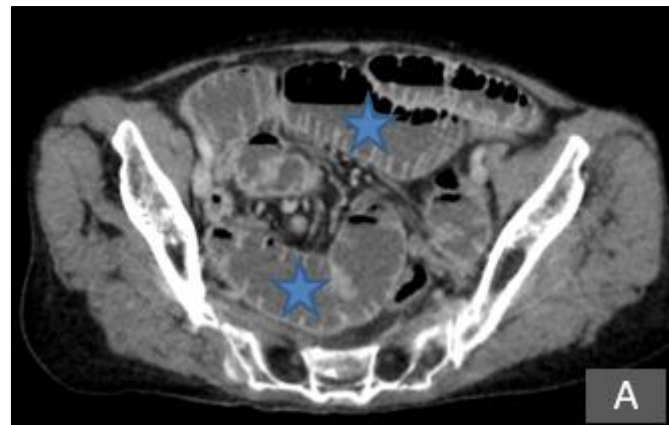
Abdominal-pelvic CT scan after portal injection of PDC; A: Intestinal dilatation of the small intestine with a hydroaeric levels (asterisk) upstream of an intestinal loop (arrowhead) located between the external obturator (red area) and pectineal muscles (yellow area) corresponding to a mechanical occlusion upstream of a right obturator hernia
